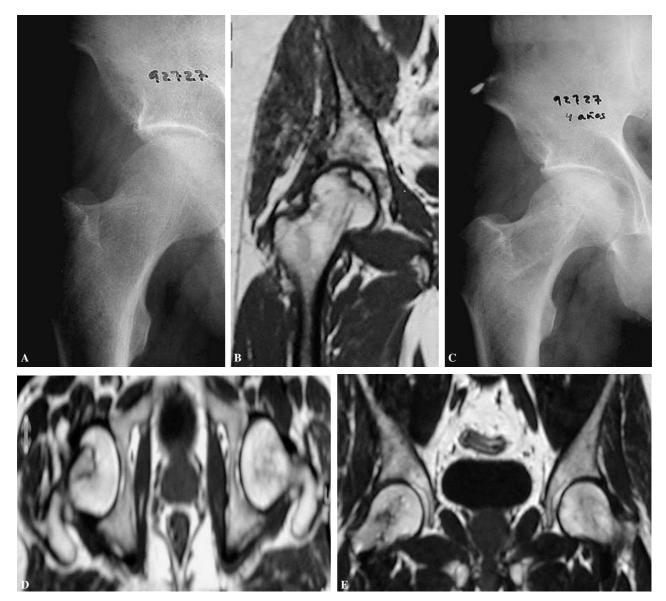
(A and B) X-rays and nuclear MRi of a stage IIb aseptic necrosis. (C) Post-op control showing graft incorporation with no radiological evolution of the necrosis. (D and E) Nuclear MRi showing graft incorporation and no necrotic signs at 4.5 years..
